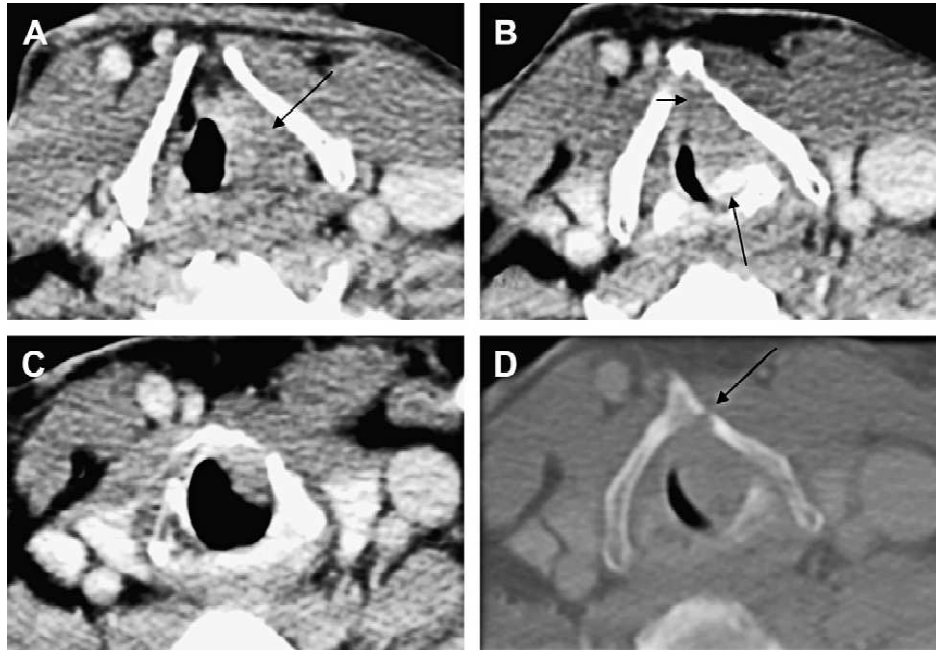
Transglottic tumor with thyroid and arytenoid cartilage invasion. Axial CT images show paraglottic (A), glottic (B, D), and subglottic (C) tumor extension.
